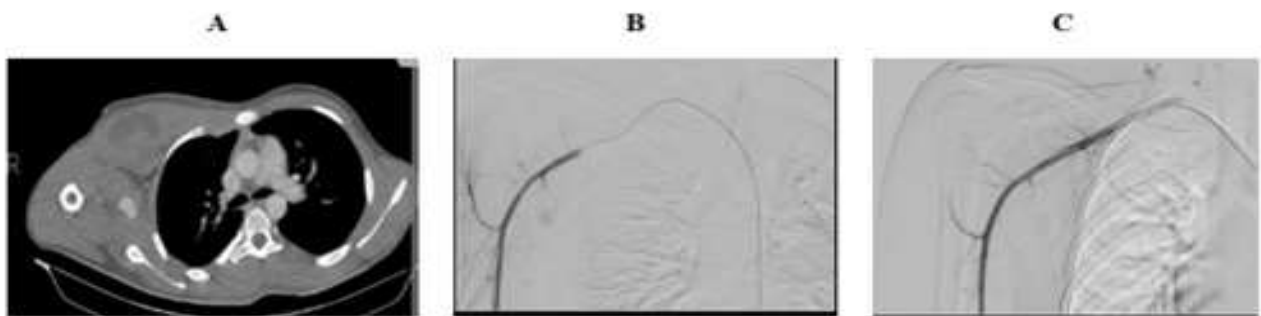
A 30-year-old patient with Subclavian PA following a stab wound to the right hemi thorax. (A) contrast-enhanced computed tomography (CT) demonstrates a Subclavian PA with narrow stock. (B) Angiography shows subclavian PA with active extravasation of contrast. (C) PA is filled by the coil, and normal blood flow in the Subclavian artery is observed.
